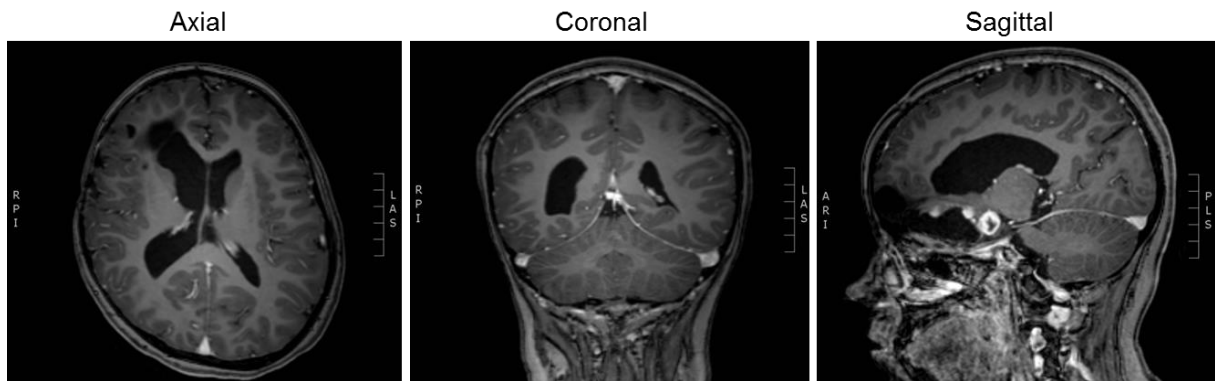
Common imaging planes used in clinical MR imaging. The imaging planes from left: axial, coronal and sagittal. The post-contrast T₁-weighted images are from a patient with optic pathway glioma.
